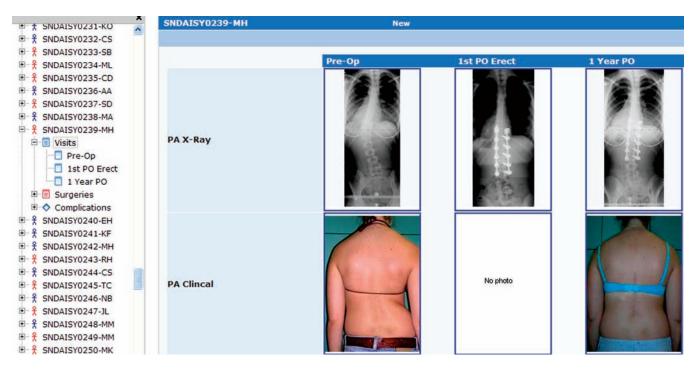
Example of database design encompassing clinical photographs and radiographic images.
